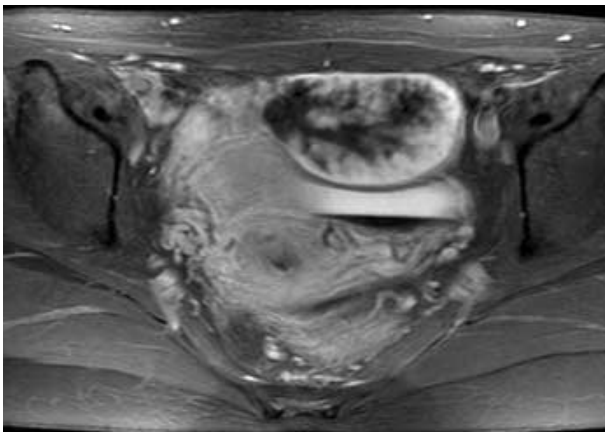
On pelvis MRI, there is a 5.5×5 cm-sized mass with high signal intensity in left ovary.
